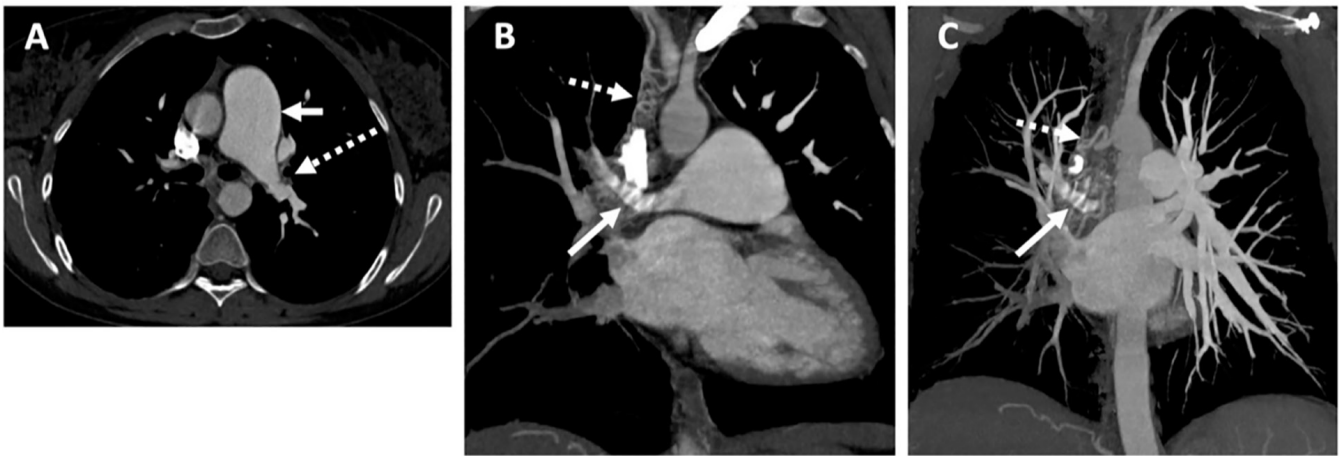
Axial CT angiography images 1 year after the treatment (A) shows enlarged main pulmonary artery (arrow). Also, luminal narrowing and wall irregularity of left interlobar pulmonary artery is observed (dashed arrow). Coronal oblique (B) and coronal (C) maximum intensity projection (MIP) images show narrowed right upper lobe pulmonary artery (arrow) and multiple collaterals in mediastinum (dashed arrow). The right interlobar, right middle and lower lobe pulmonary arteries are occluded. On coronal MIP image (C), diminished pulmonary arterial vasculature is observed in the right lung compared to the left.
